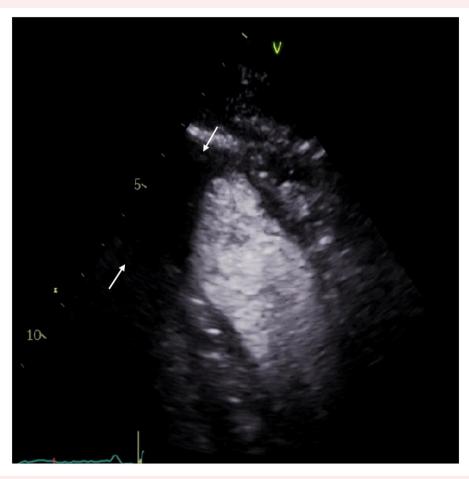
Transthoracic echocardiogram with intravenous contrast demonstrating apical inferior/infero-septal segment area filling defect (arrows), favoured in this context to represent mural thrombus.
